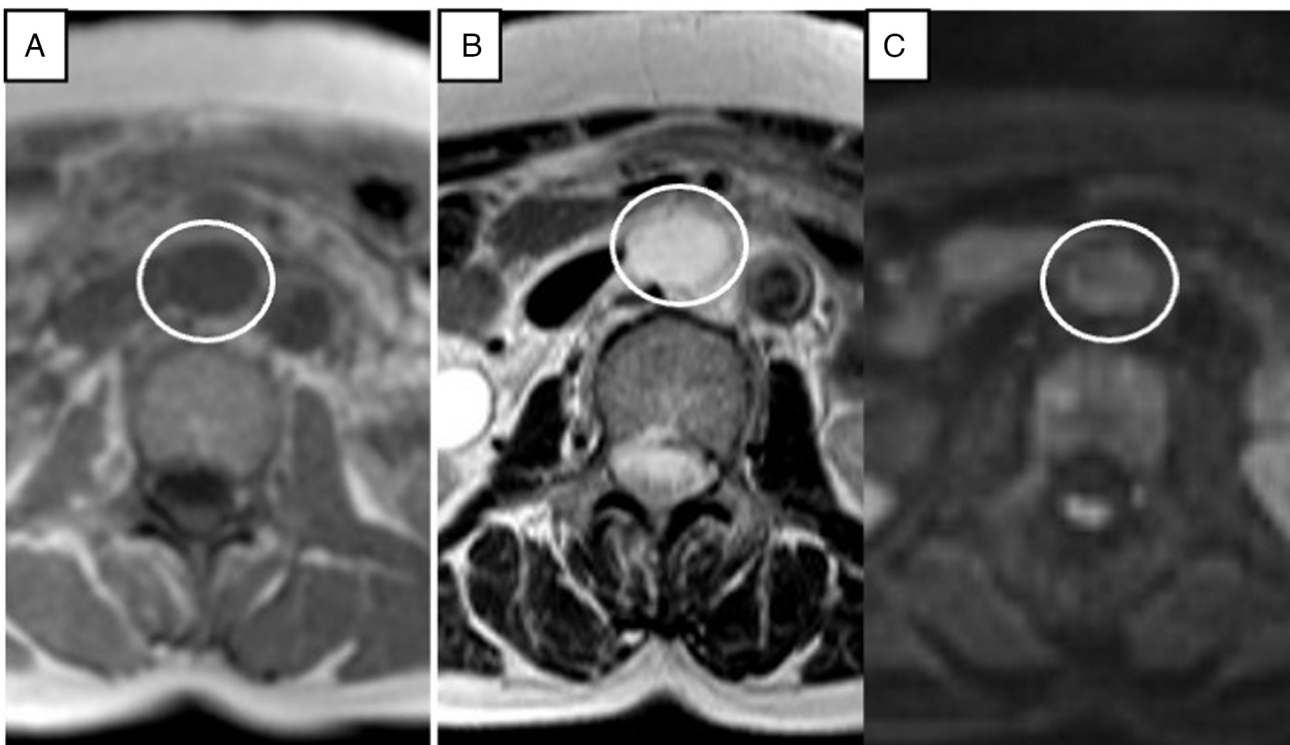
First pre-contrast-enhanced abdominal MRI scan. The white circle indicates the retroperitoneal tumor. (A) A circular homogenous low-density area on T1-weighted imaging. (B) Linear and curvilinear low-signal-intensity areas within the circular high-density area on T2-weighted imaging. (C) An iso-density area on diffusion-weighted imaging.
